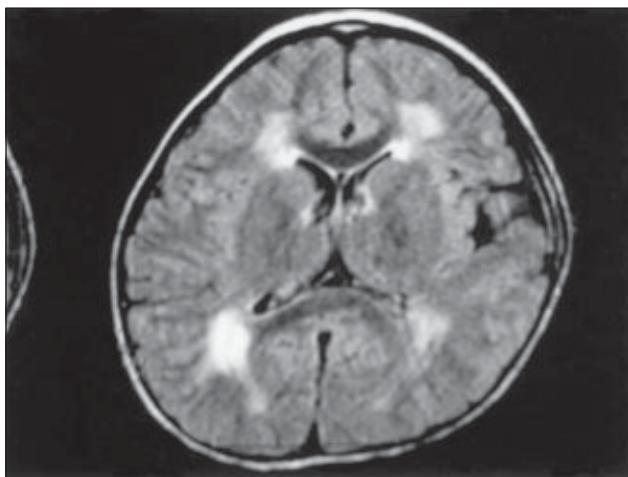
Magnetic resonance image showing the periventricular deep white matter, which demonstrates abnormal T1W hypointensity and T2W hyperintensity, in a bilateral symmetrical fashion. The subcortical U-fibres are relatively spared, with the changes most prominent in the peritrigonal region
